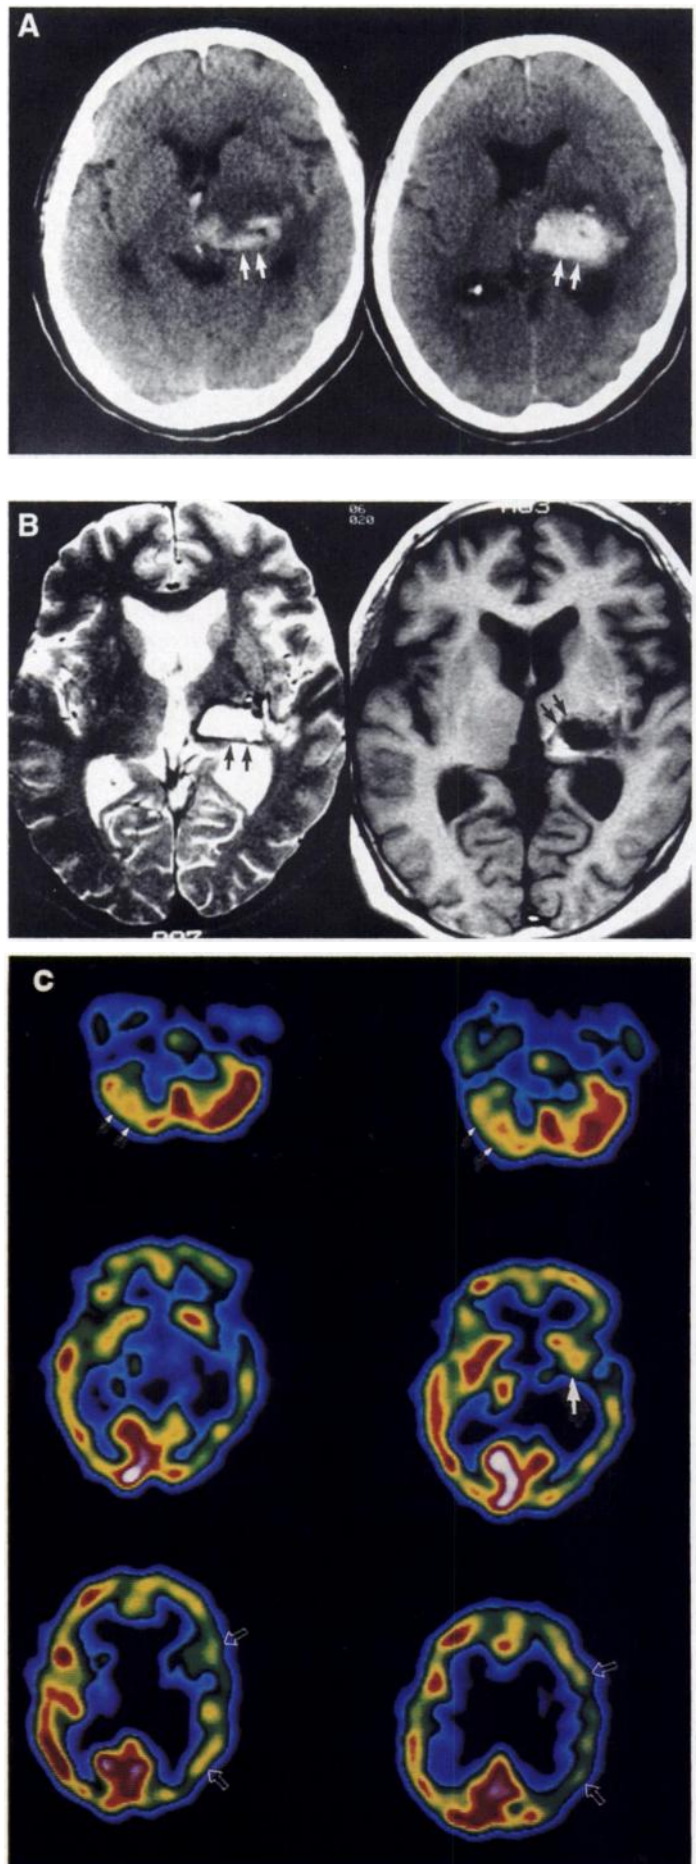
Diaschisis in patient with thalamic hematoma. (A) Initial CT shows intracranial hematoma in thalamus at hemorrhagic attack (arrows). (B) Follow-up MRI shows strictly confined hematoma in thalamus without cortical structural abnormality on T2- and T1-weighted images (arrows). (C) Reduction of regional cerebral blood flow in contralateral cerebellum (small arrows), affected thalamus, ipsilateral basal ganglia (closed arrow) and cerebral cortex (open arrow) are demonstrated.
